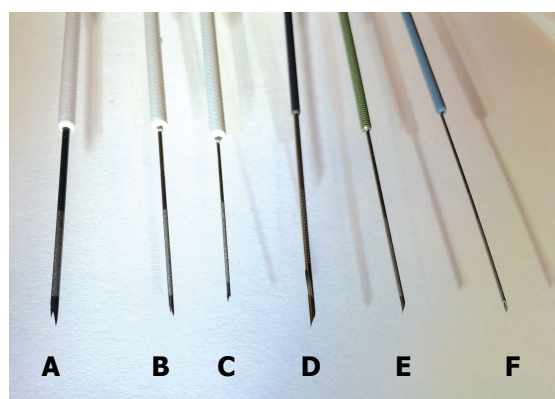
Representative endoscopic ultrasound biopsy and fine needle aspiration needles. A: 19G core biopsy needle; B: 22G core biopsy needle; C: 25G core biopsy needle; D: 19G FNA needle; E: 22G FNA needle; F: 25G FNA needle.
